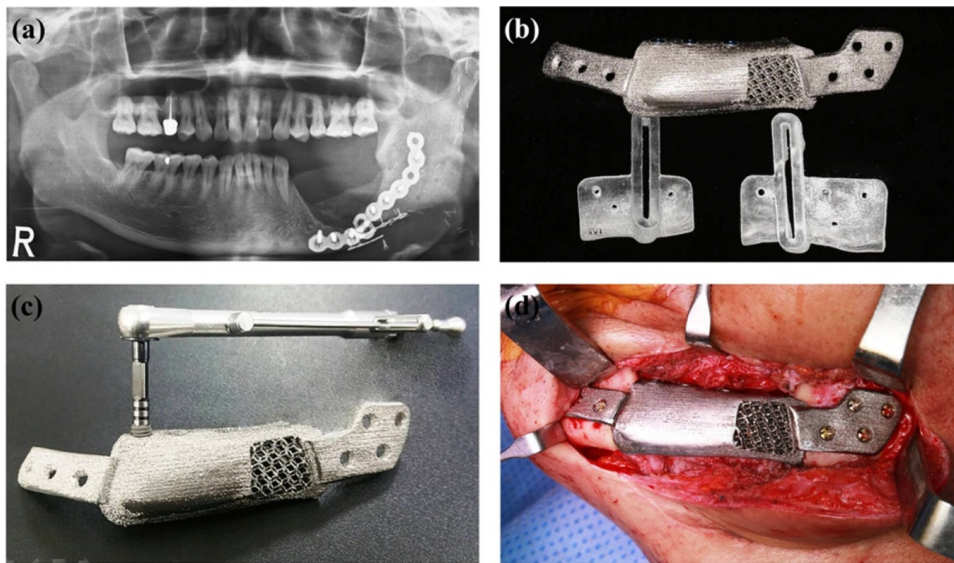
Mandible reconstruction using 3D printed pre-mounted dental implants (a); Computed tomography image of patient showing pathologic fracture of the left mandibular body (b); 3D-printed titanium mandibular implant and resection guide (c); The titanium mandibular implant installed with dental implant fixtures (d) 3D printed titanium implant was implanted to the resected area of the left mandibular body [84]
